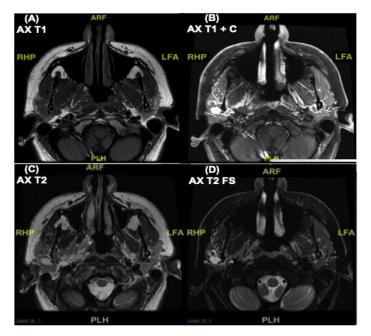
Axial MRI cuts at the middle of the first component of the lesion, located in the right parotid gland. (A) Axial T1-weighted MR image revealing a well-defined hypointense lesion that contains multiple cystic components with vascular content and several nodules corresponding to phleboliths. (B) Axial T1-weighted MR image with contrast showing the same image as (A) but with intense enhancement of the tumor. (C) Axial T2-weighted MR image displaying the same image as (A) but the tumor is hyperintense. (D) Axial fat-saturated T2-weighted MR image exposing the same image as (C) but the tumor is easier to visualize because of the fat saturation.
